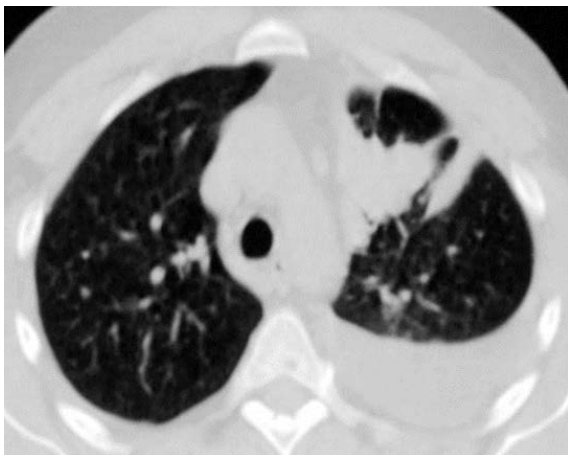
Chest computed tomography scan shows a tumor in the left lung with pleural effusion.
